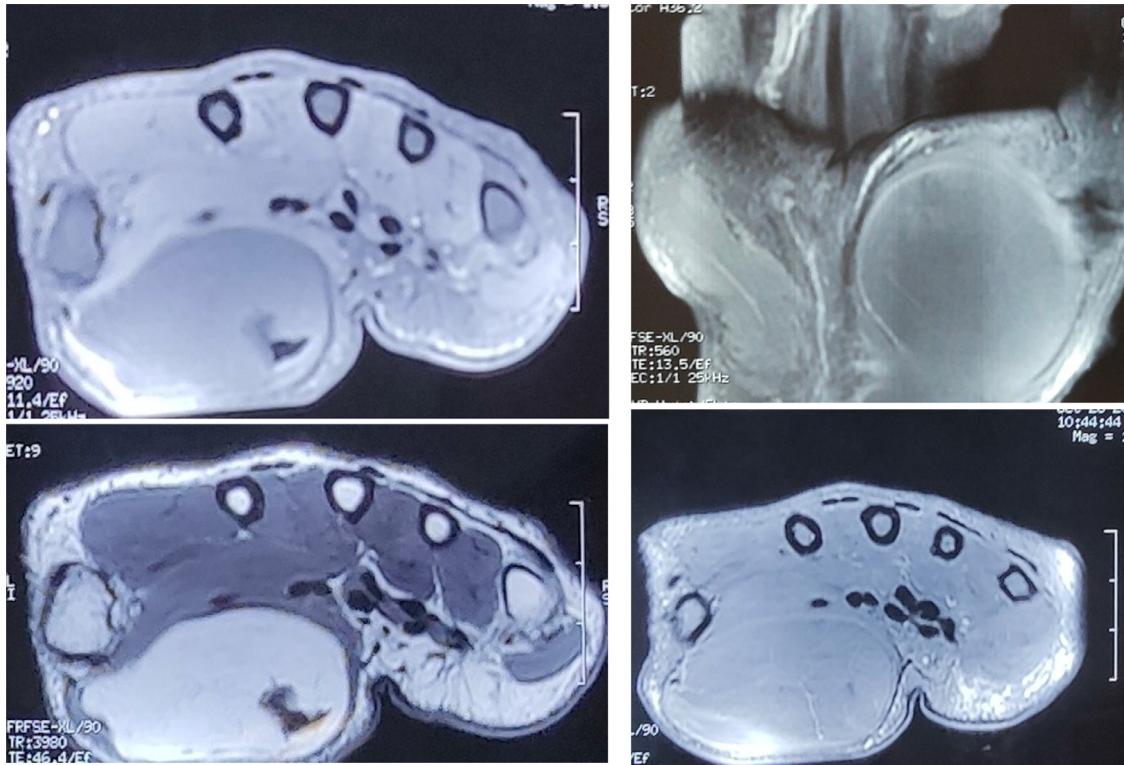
MRI showing the underaponeurotic mass of the thenar mass.
